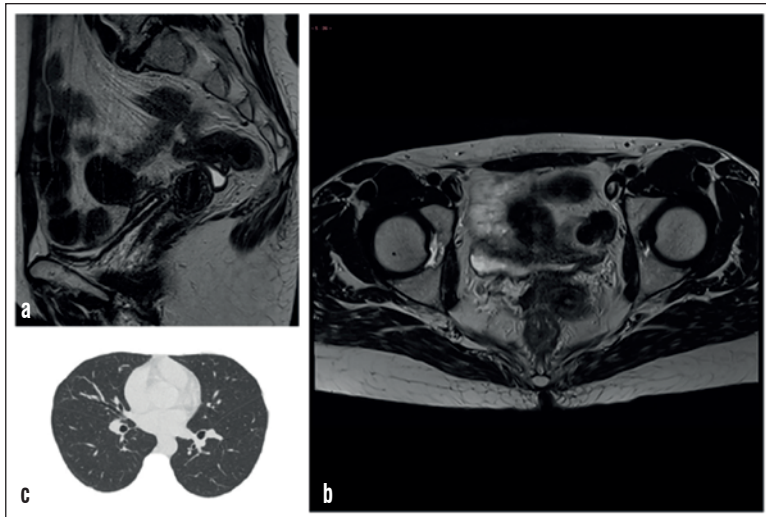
Follow up (February 2020): a) Sagittal and b) axial pelvic MRI scans with part of cervix - without signs of tumor recurrence, c) non-contrast axial scan of thorax after treatment -without signs of disease in lung parenchyma
